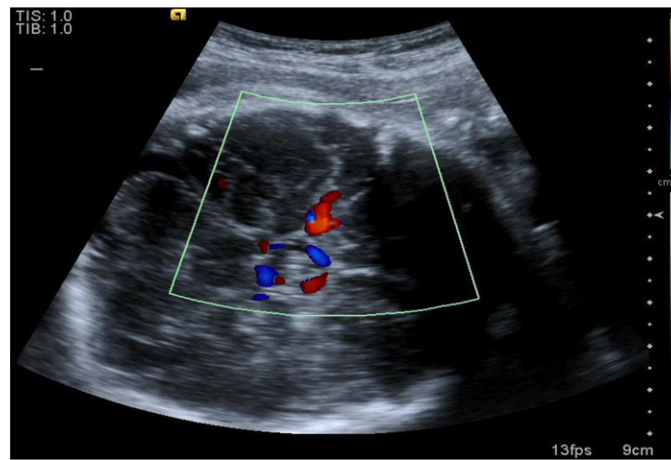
The middle cerebral artery imaged using color Doppler.
